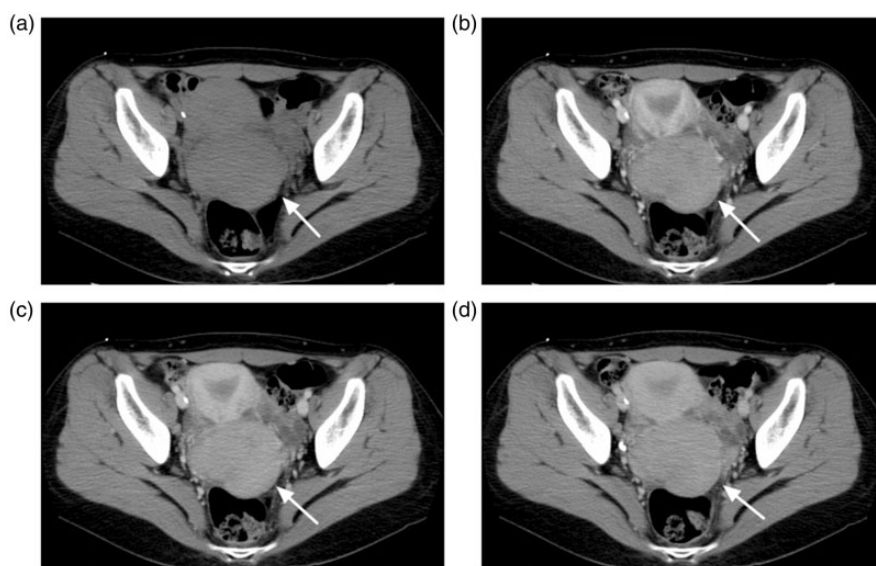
Dynamic CT images: (a) non-enhanced, (b) arterial phase, (c) portal phase, (d) equilibrium phase. Dynamic CT showed gradual enhancement. Non-enhanced CT revealed a high-density mass (48 HU).
